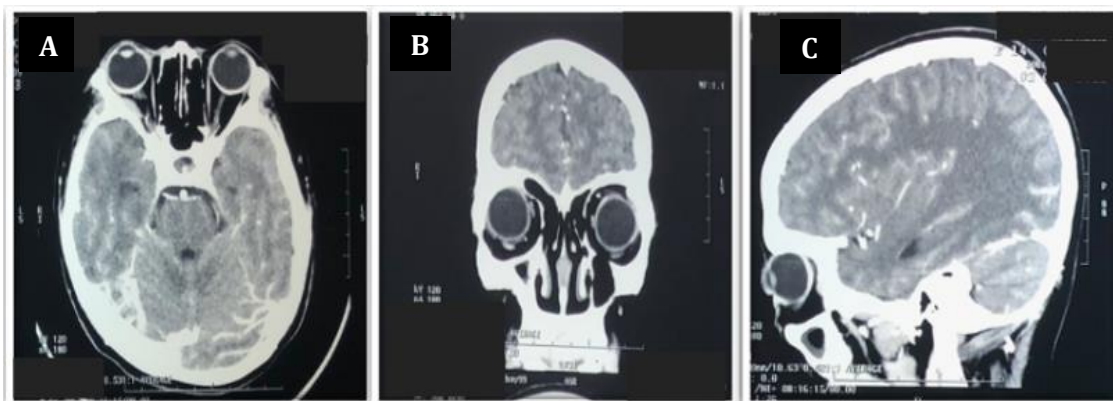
Head orbital CT scan with contrast ten months post-surgery and complete antituberculosis treatment. (A) Axial, (B) coronal, and (C) sagittal plane shows no evidence of retroorbital mass of the right eye.
